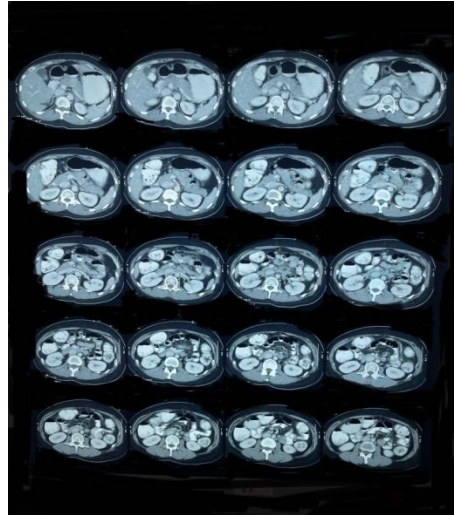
CT IMAGE SHOWING THE INTUSSUSCEPTION
